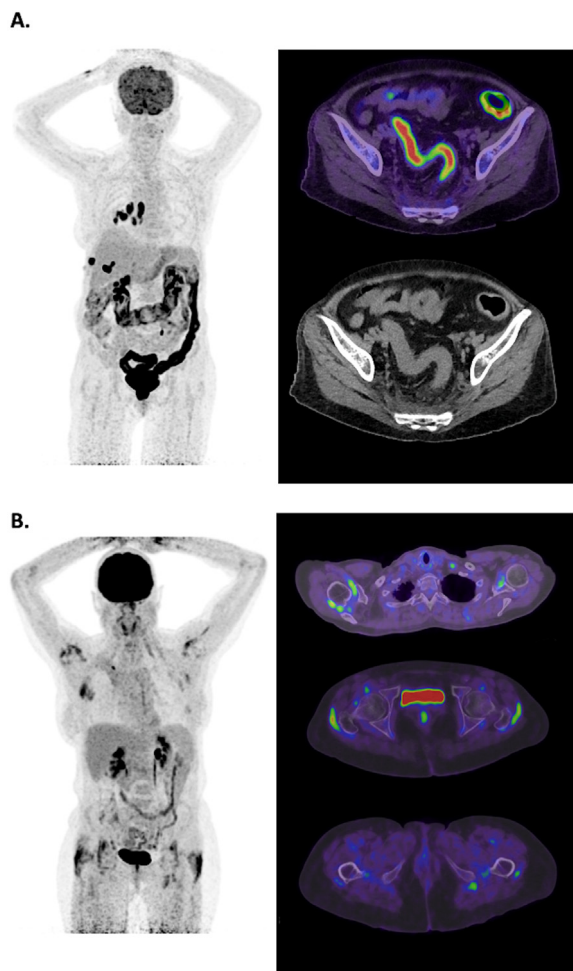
irAEs as potential surrogate of immunity response capabilities. The overall metabolic load of immune reactivity assessed by FDG-PET at the body level may be a holistic biomarker of personalized autoimmune response potential. (A) colitis in a patient with lung cancer stage IV under immune checkpoint inhibitor therapy (anti-PD-L1, Durvalumab). (B) PMR-like syndrome in a patient with lung cancer stage IIIB under immune checkpoint inhibitor therapy (anti-PD-L1, Durvalumab).
